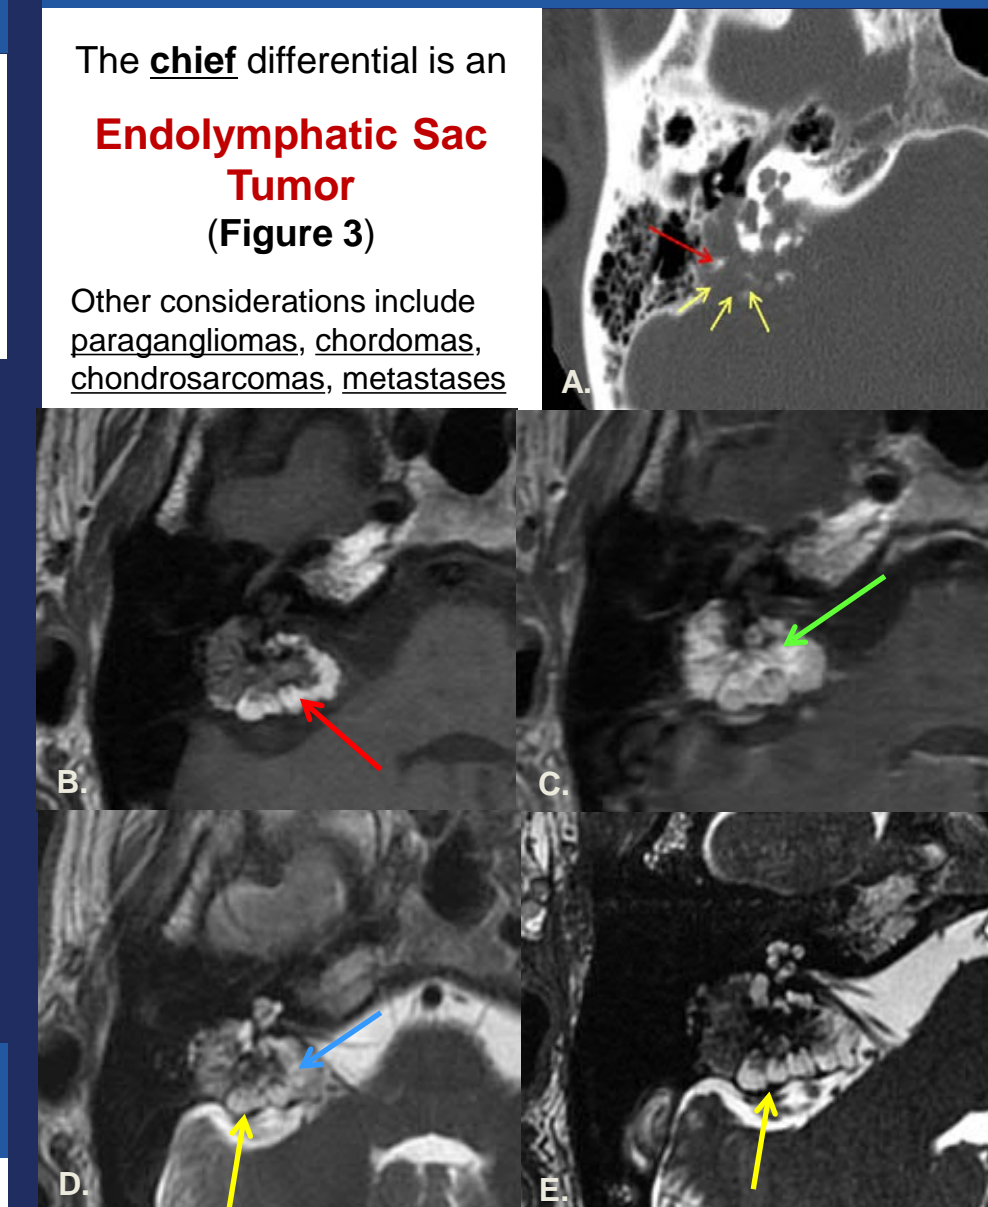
Endolymphatic Sac Tumor Imaging Characteristics. (A) CT scan demonstrating permeative osseous destruction (yellow arrows) and central spicules of calcification are commonly seen (red arrow). Typical MRI imaging characteristics are demonstrated. (B) T1WI: Peripheral T1 hyperintensity is common, often in the shape of small T1 hyperintense cysts (red arrow). (C) On post-contrast T1-weighted MRI, the central non-cystic component of the mass enhances avidly (green arrow). (D) T2-weighted image demonstrates heterogeneous T2 hyperintensity (blue arrow). Peripheral hemosiderin is seen as a T2 hypointense rim (yellow arrow). (E) The peripheral cysts and hemosiderin rim (yellow arrow) are better appreciated on a high-resolution FIESTA sequence.
